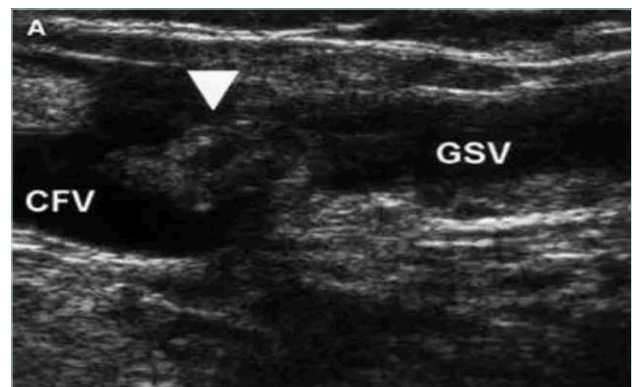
Ultrasound appearance of endothermal heat-induced thrombosis (EHIT), when thrombus has extended into the deep vein from the saphenous vein.
